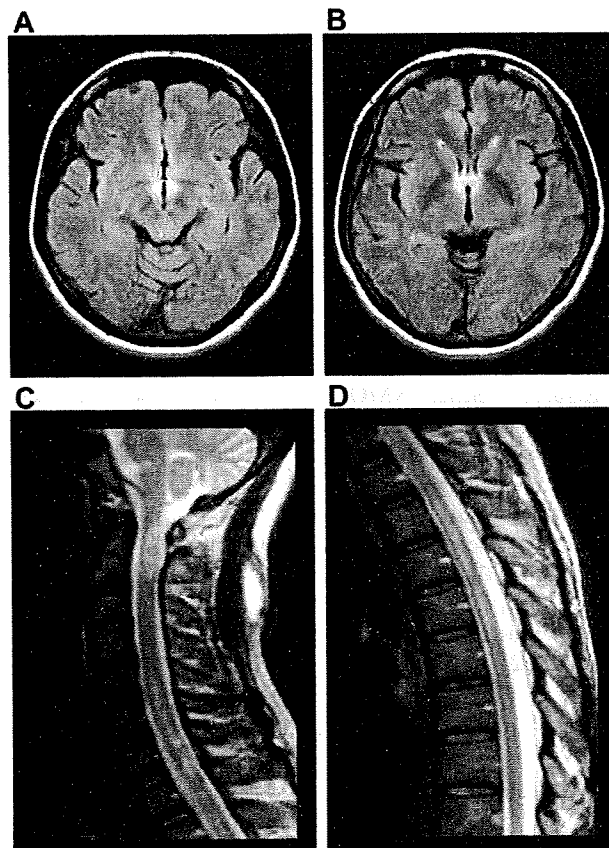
Brain axial fluid attenuation inversion recovery magnetic resonance images show hyperintensity areas involving bilateral symmetrical hypothalami (A) and periaqueductal lesions (B). Spinal sagittal T2-weighted magnetic resonance images show hyperintensity areas of the cervicothoracic cord from the C6 level to the Th7 level and of the cervical cord at the C2 level (C) with mild swelling (C and D).
